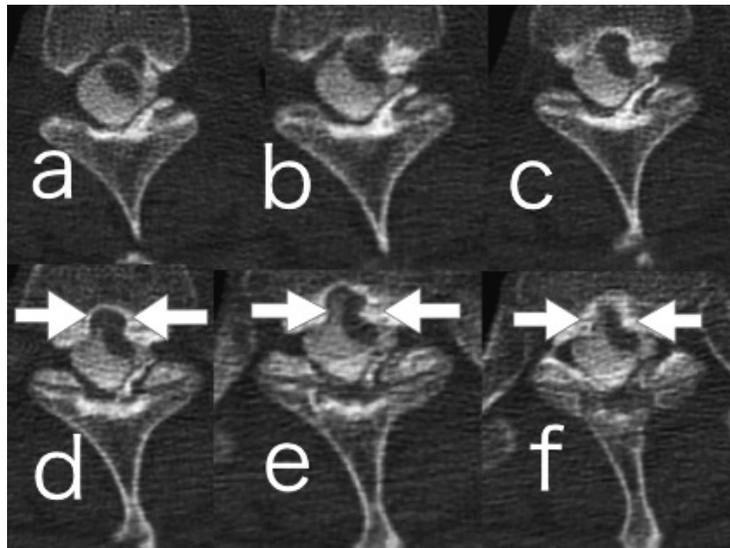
(a, b, c, d, e and f) Preoperative CT myelography (axial section), rostral (a) to caudal (f) view. An osteophyte has formed a hemisphere-like cavity (arrow), and the spinal cord in the right anterolateral side has herniated into the cavity. The CSF signal has disappeared into the ventral side of the cord.
